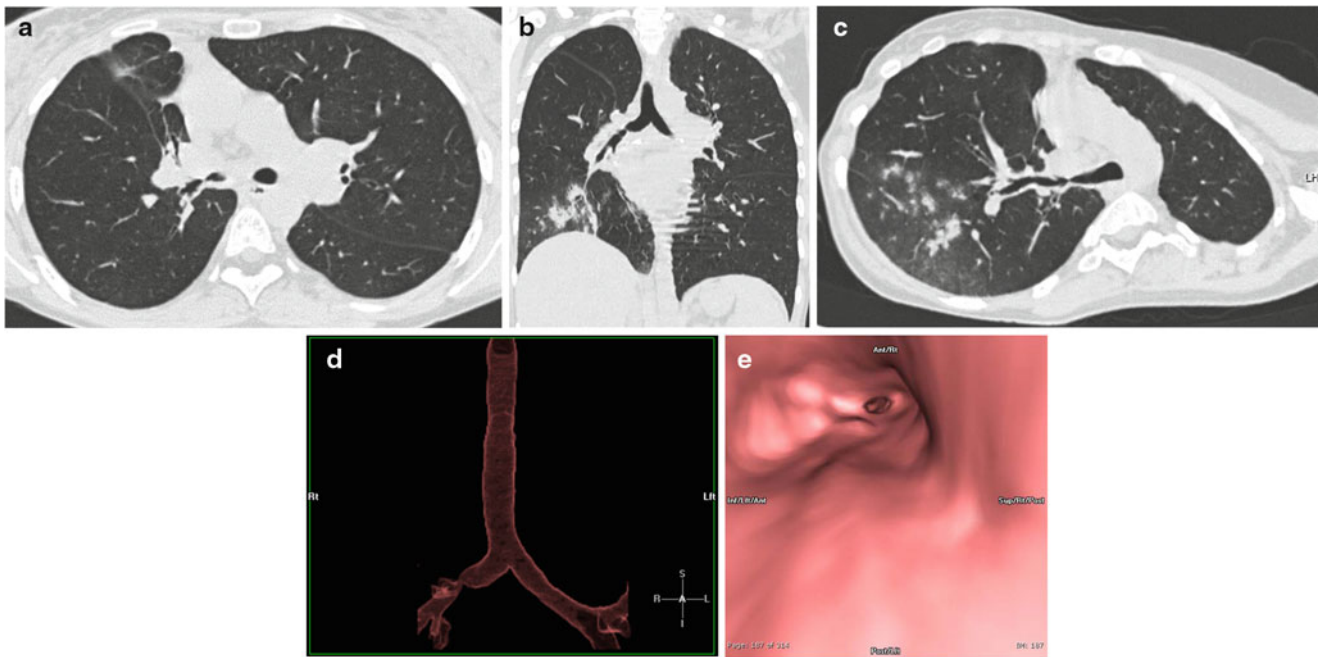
Nonenhanced thin-section CT scan of a 26-year-old female who underwent bilateral lung transplantation 6 months before due to cystic fibrosis. She went to hospital due to recurrent fever, emesis with some nonproductive cough, and global deterioration. FEV₁ was 2.31 (71%). CMV pp65 antigenemia was mild positive (260 IU/ml). Bronchopneumonic infiltration was evident on CT in the *right lower lobe* (B+C) as well as the causal stenosis of the *right main stem bronchus* (a). Multiplanar reformat and postprocessing helped to identify the stenosis and to quantify its severity and extent (b, c, d). Virtual bronchoscopy was calculated for demonstration purposes and matches well with real bronchoscopic view. Biopsy was taken to differentiate between graft rejection and infection (the latter was the reason). (a) Transversal CT scan, (b) coronal reformat, (c) paracoronal reformat (single oblique), (d) surface-shaded rendering, (e) virtual bronchoscopy
